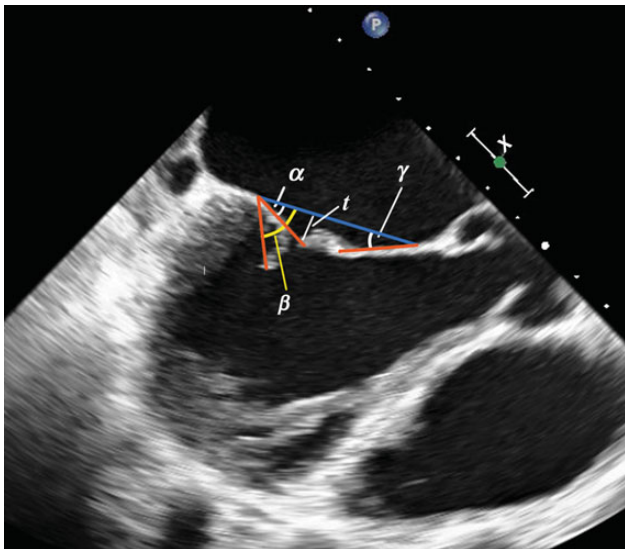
Preoperative transoesophageal echocardiography at a long-axis view in mid-systole. α shows the posterior leaflet tethering angle. β shows the posterior leaflet atriogenic tethering angle (yellow line). γ shows the anterior leaflet tethering angle. The blue line shows the antero-posterior diameter of the mitral annulus (A2–P2). Tenting height was determined by the distance between the point of leaflet coaptation and the mitral annular line (t).
